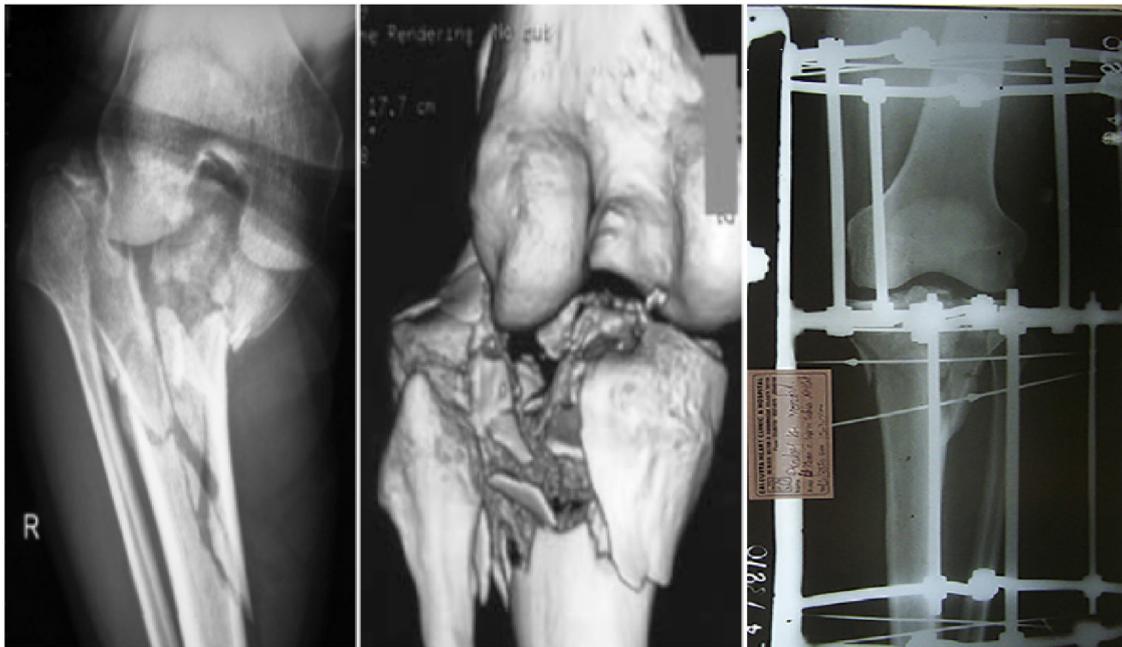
The Xray and CT images showing the Comminuted tibial plateau fracture with intact fibula, buttressing effect of fibula with fibular transfixation wire.
